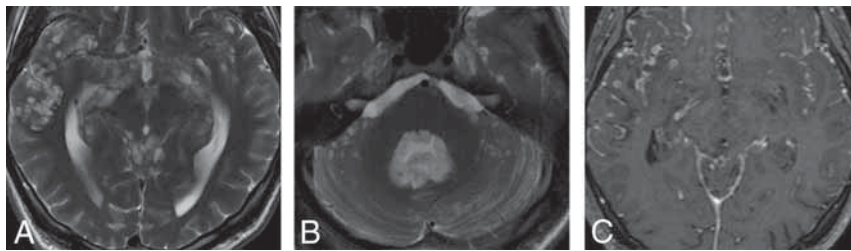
Diffuse leptomeningeal glioneuronal tumor in a 20-year-old man previously diagnosed 10 years earlier. Multiple superficial small cystlike lesions are seen in the brain sulci, basal cisterns, cerebellar folia, and filling the fourth ventricle (A and B). Also note extensive irregular leptomeningeal enhancement (C). Axial T2-weighted images (A and B). Axial T1-weighted fat-saturated contrast-enhanced image (C).
